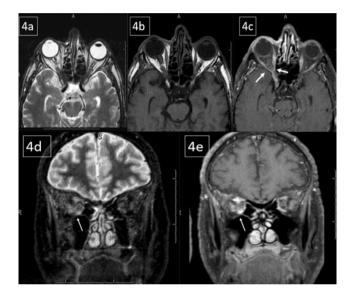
Orbital magnetic resonance imaging: The right orbital apex appeared overcrowded on axial T2-weighted (a), precontrast axial (b) and postcontrast (c) T1-weighted, coronal fat-suppressed T2-weighted (d), and postcontrast coronal fat-suppressed T1-weighted (e) images, and was especially pronounced in the postcontrast fat-suppressed axial and coronal T1-weighted sections (c and e). This appearance was caused by edematous thickening of the optic nerve sheath, contrast enhancement, and streaking in the fatty tissue
